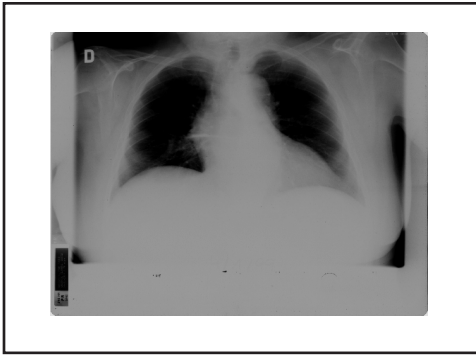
Chest x-ray of patient 1. Observe the decreased number of intercostal spaces as well as the absence of pleural and parenchymal lung disease.
